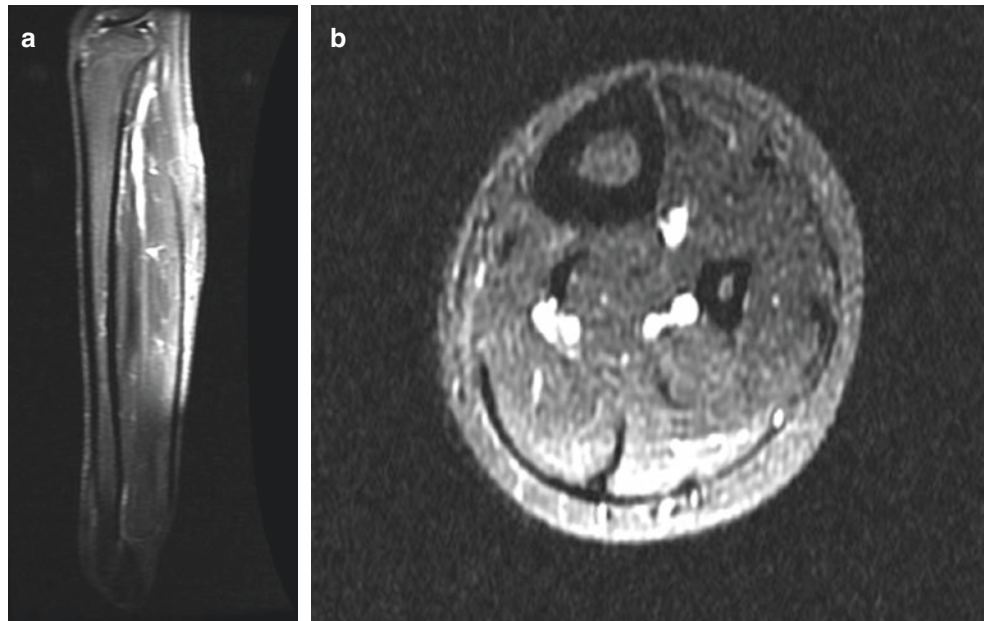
(a–c) MRI Scan of a young female athlete showing bone marrow edema appreciated as hypointense signal on T1 weighted and hyperintense signal on T2 weighted images. Note the periosteal edema on STIR axial images
